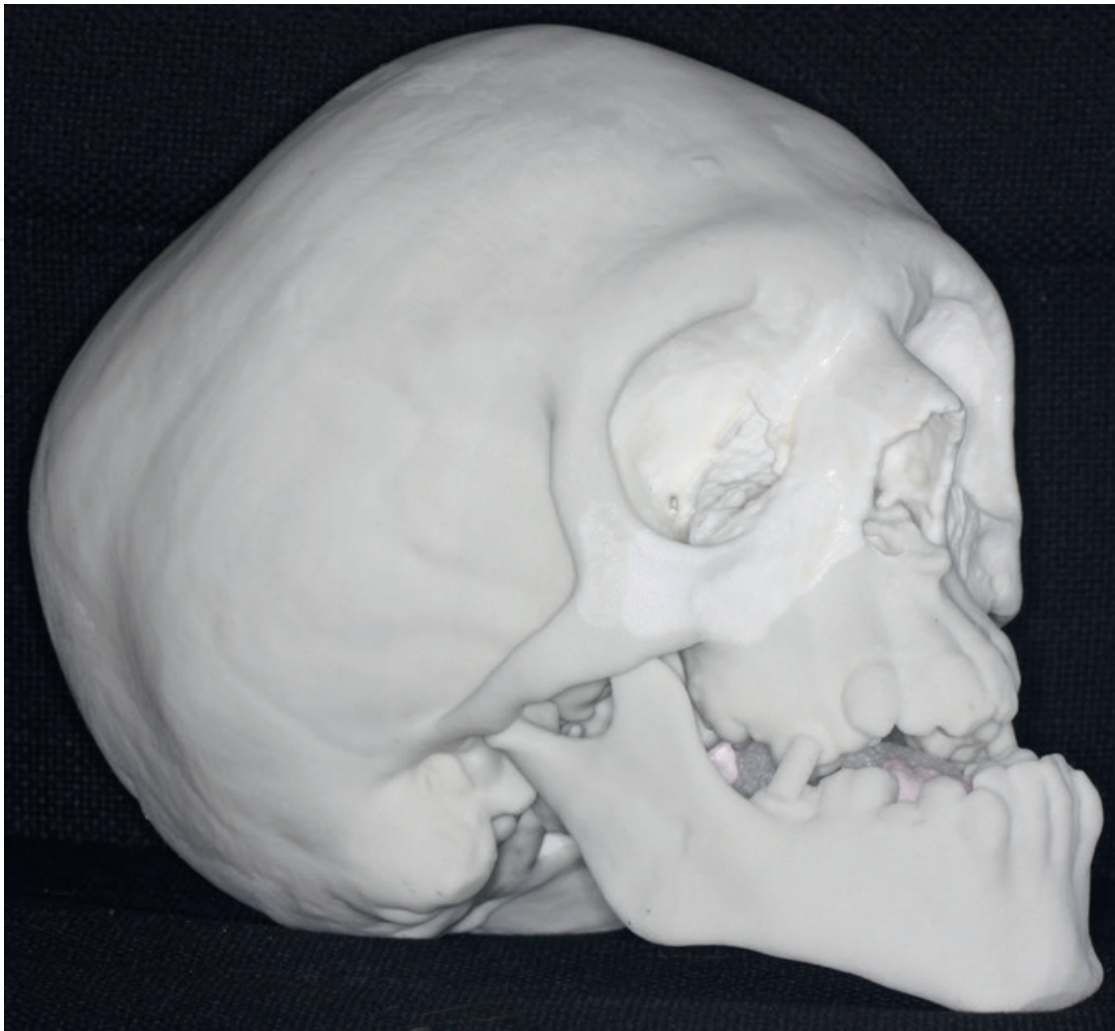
Presurgical 3D model of a case with Crouzon syndrome obtained from CBCT.
